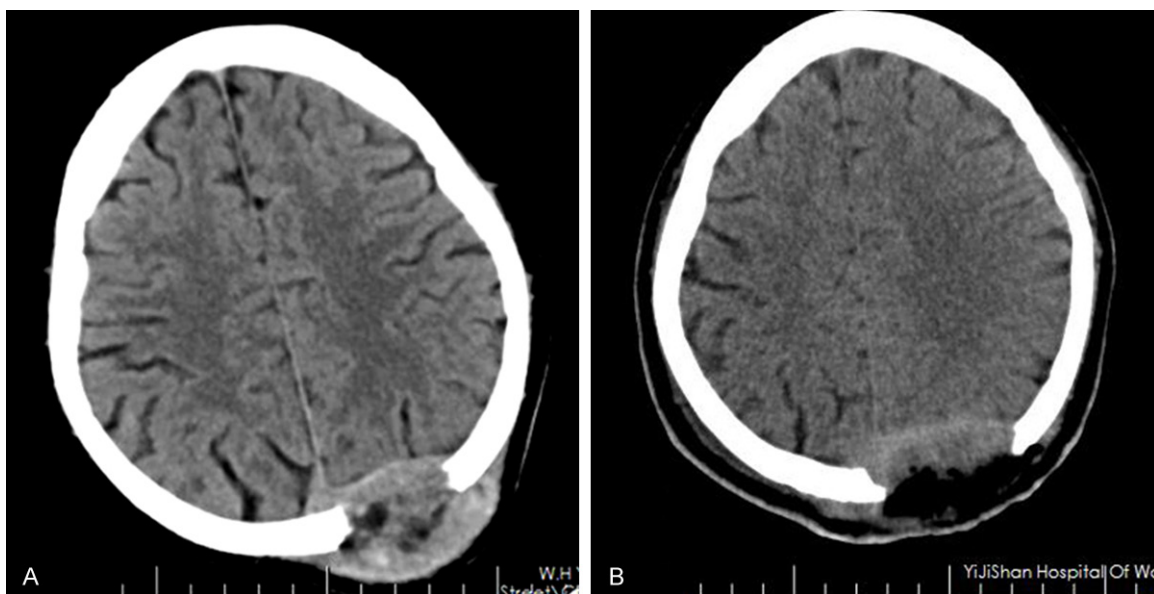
A. Head CT scan exhibited an occipital mass, 6.0 cm×8.0 cm in size, isodense with central necrosis, and with osteolytic destructive features. B. The tumor was gross total resected.
